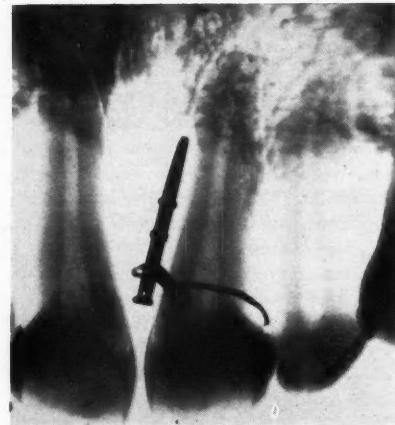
Labial and lingual wires superimposed. X-ray tube correctly angled. Depth of pocket is from tip of point to attachment of wire.
